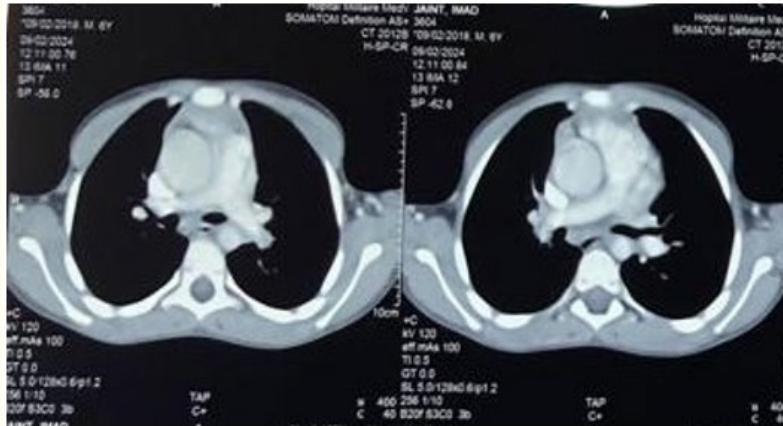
Thoracic Angio CT confirming the coarctation of aorta.
